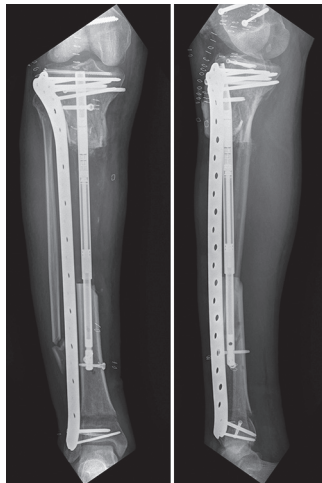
A/P and lateral radiographs demonstrating a tibial spanning plate, fully extended Precise nail, and distal tibial corticotomy with plans for retrograde tibial bone transport
